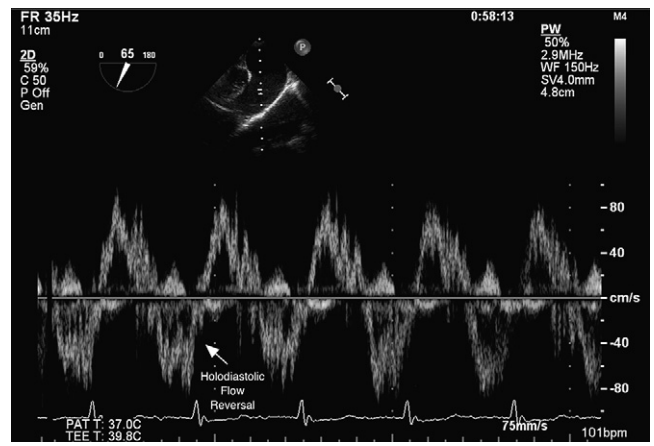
Pulsed-wave Doppler recorded in the pulmonary artery obtained by transesophageal echocardiography shows holodiastolic flow reversal.
